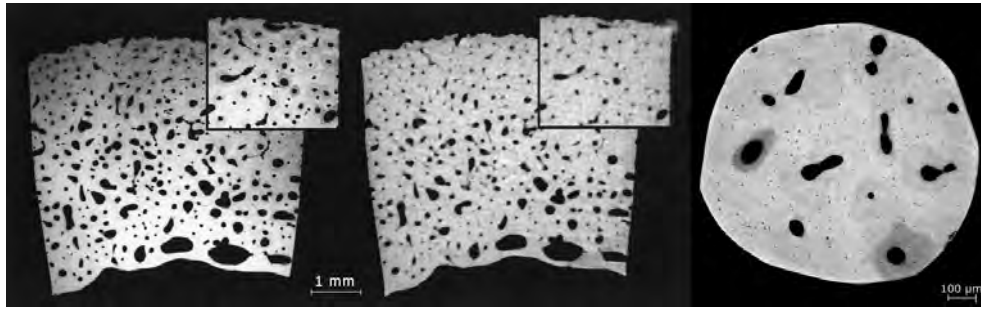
An example of a cross-sectional image sets taken in 2004 with a micro-radiograph (left) and μ CT (middle) by Cooper *et al.* [59], and (right) a μ CT scan produced in the present study. In both cases the samples were cortical bone. It is evident that a superior detail resolution can be achieved with a good μ CT of today in comparison with a radiograph of 2004. Back then the smallest Haversian canals were at the limit of distinguishable detail when today the lacunae have the same status.
